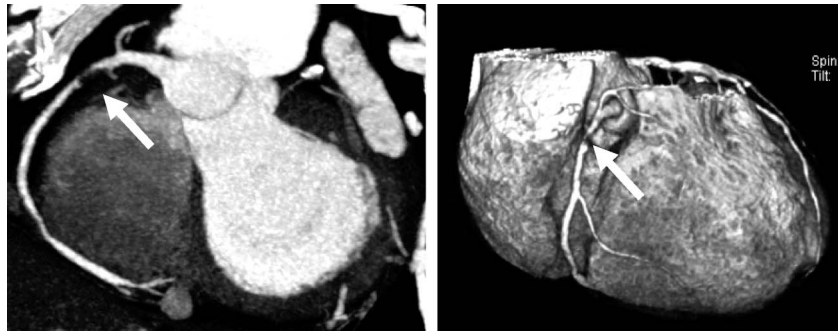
Computed tomographic coronary angiography reconstruction shows a severe stenosis in the right coronary artery (arrow).
